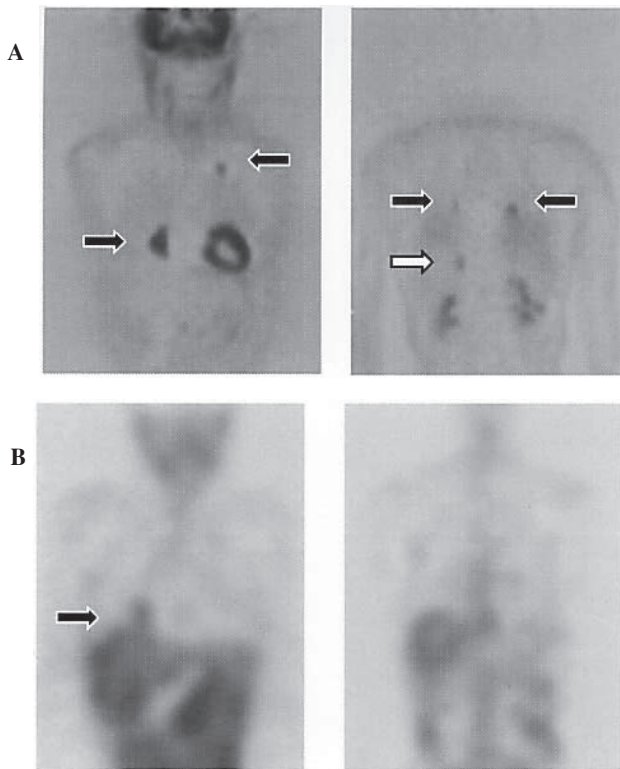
A 48-year-old man with Stage IV NHL (Patient 4). ^{18}F -FDG PET images reveal intense accumulation of ^{18}F -FDG in multiple lung lesions (black arrow) and a liver lesion (A). ^{67}Ga SPECT images reveal accumulation of ^{67}Ga limited to a single lung (black arrow) (B). This case was understaged by ^{67}Ga SPECT compared with ^{18}F -FDG PET (Stage I to IV).
